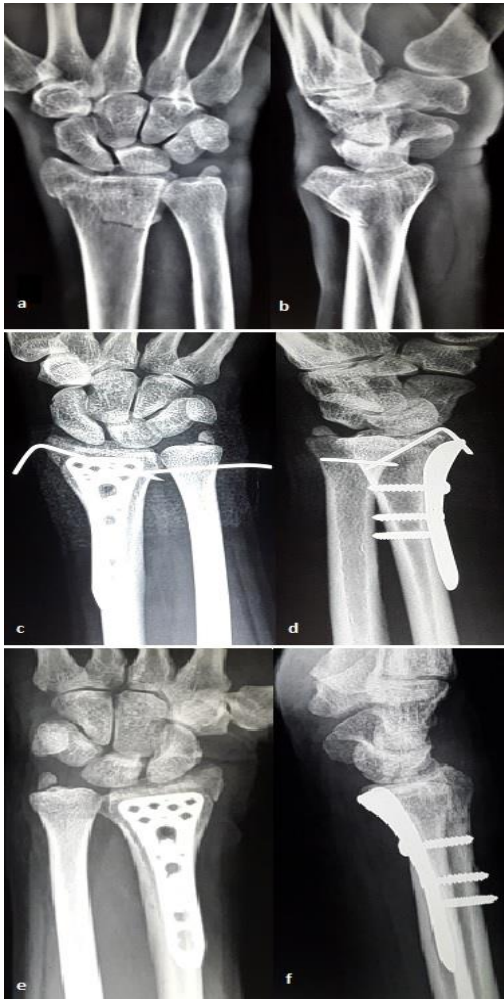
(a) Preoperative X-ray AP and (b) lateral view showing distal end radius fracture. Immediate postoperative X-ray (c) AP and (d) lateral view showing distal end radius fracture fixed with volar locking plate. Postoperative 6 month follow-up X-ray (e) AP and (f) lateral view.
